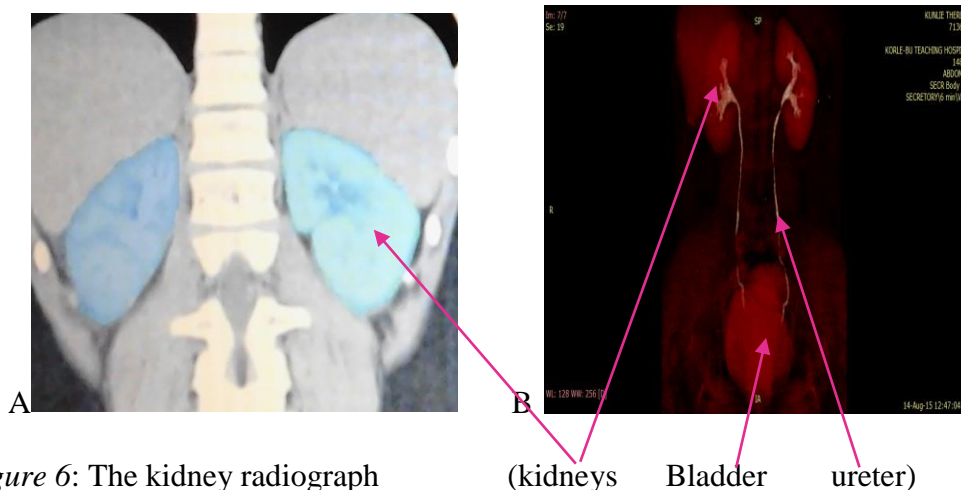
The kidney radiograph
